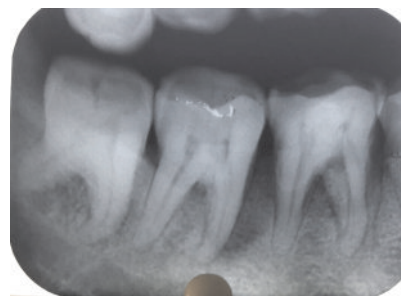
Preoperative radiographic view (mesial to 37)
